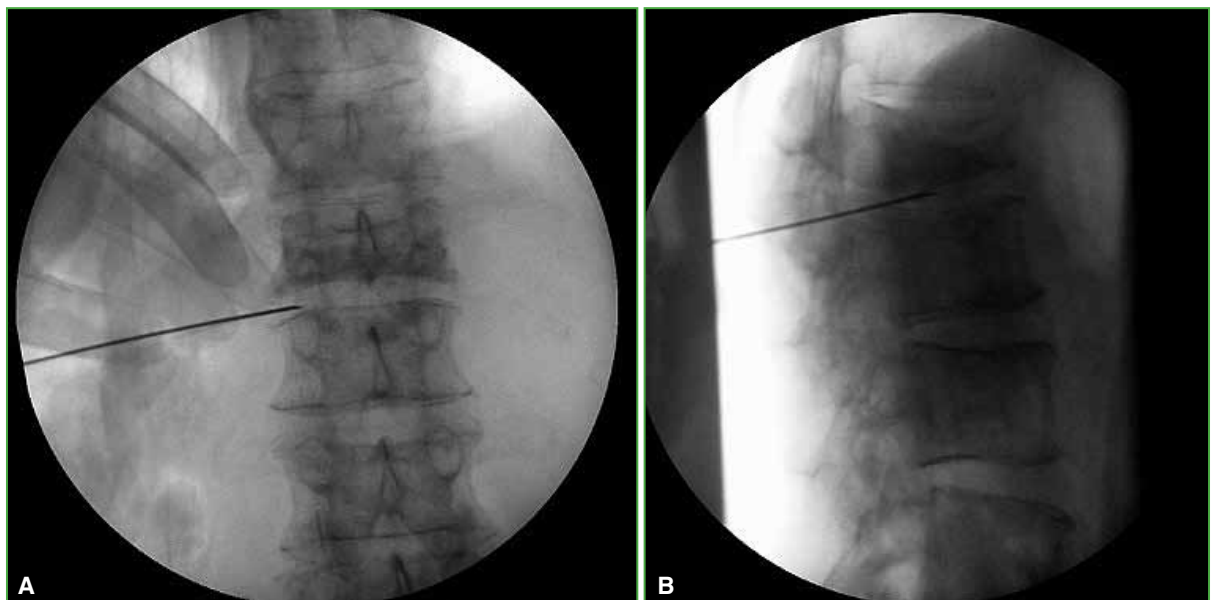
Intraoperative anteroposterior (A) and lateral (B) radiographic projections. The posterolateral entry point is visualized.
